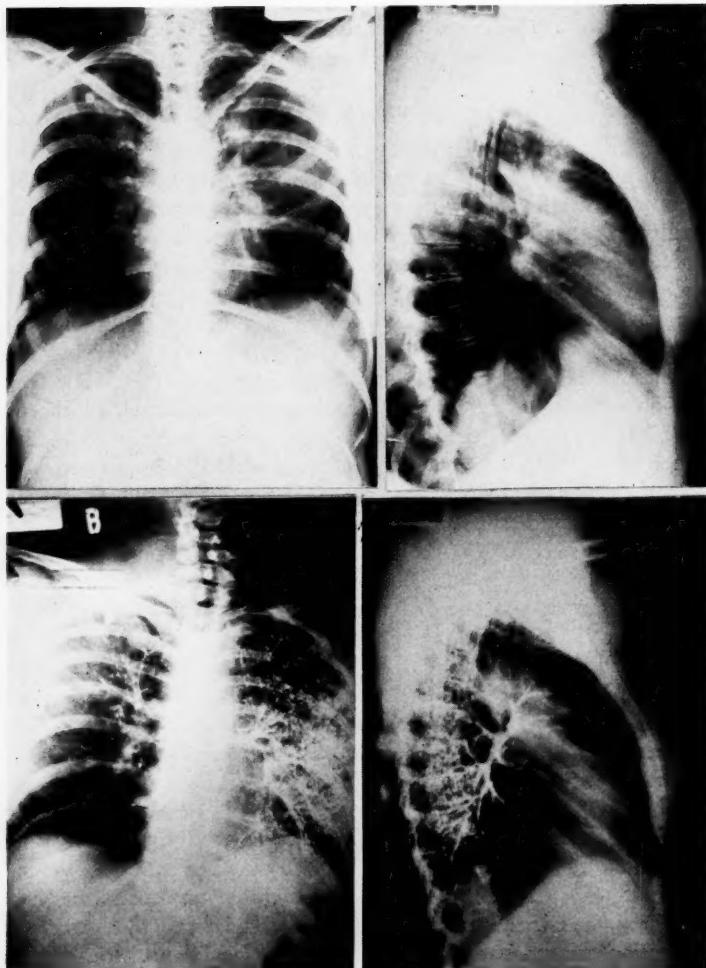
Case 1. Postero-anterior and lateral roentgenograms and bronchograms of the chest of a 49-year-old, white female whose chief complaint was paroxysms of unproductive cough of eight months' duration. Note the hazy infiltration of the upper lobe of the left lung and the elevation of the left diaphragm. The left bronchus was entirely patent. In the bronchogram the left lower lobe is seen to fill completely. Oil fails to run into the smaller divisions of the left upper lobe bronchi, but the major bronchi are patent.
